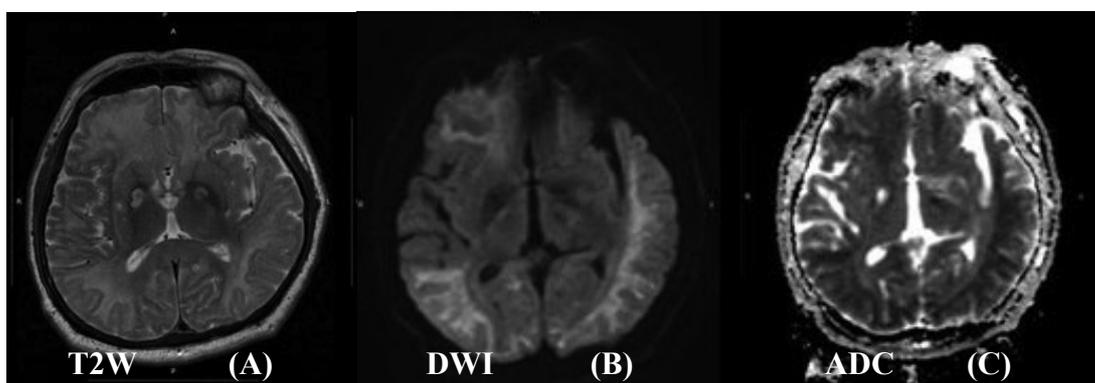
Axial T2-weighted 1.5-Tesla brain MRI (A) with DWI (B) and ADC map (C) performed six weeks after the initial presentation, showing further worsening of the cerebral white matter changes, with restricted diffusion on DWI and ADC map.
